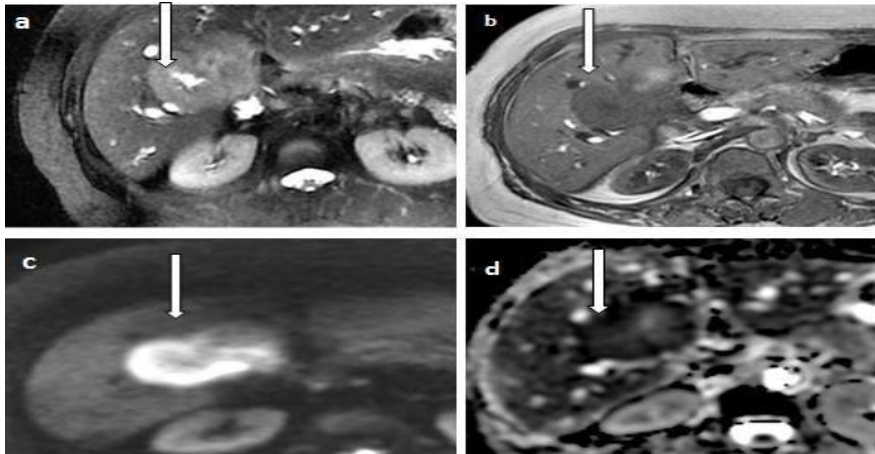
MRI of a 60-year-old female of GBC. Axial T2 image (a) shows an ill defined hyperintense signal intensity mass (arrow) in GB fossa which is hypointense (arrow) on axial T1-weighted (b) image. The DWI image (c) ($b=1000 \text{ s/mm}^2$) (arrow) shows hyperintense signal and corresponding ADC map (d) shows diffusion restriction (arrow).
